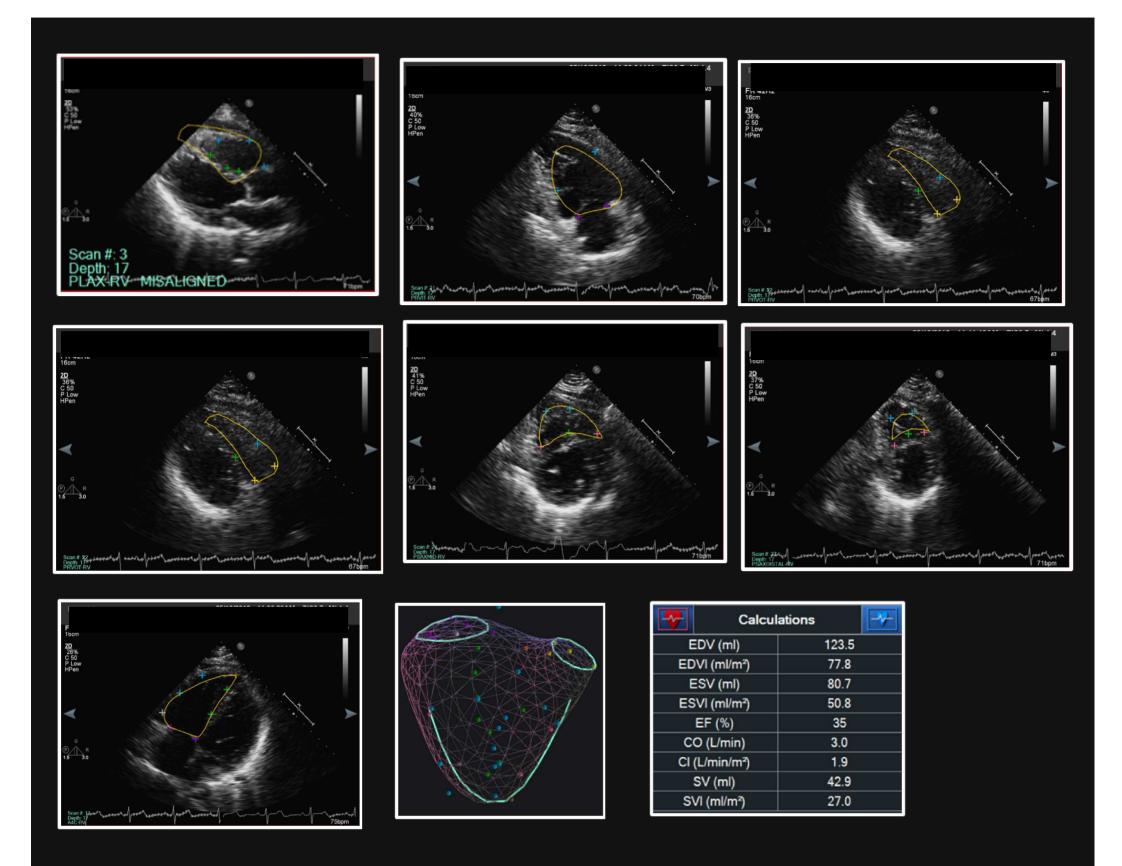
Patient Case 3 with views , 3D model, and calculations for Right Ventricle. (A) RV Parasternal Long Axis, (B) Parasternal Right Ventricular Inflow Tract, (C) Parasternal Right Ventricular Outflow Tract, (D) Parasternal Short Axis Aortic Outflow, (E) Parasternal Short Axis Mid , (F) Parasternal Short Axis Distal, (G) Apical 4 Chamber, (H) 3D Model of ED RV, (I) Calculations for ED and ES.
